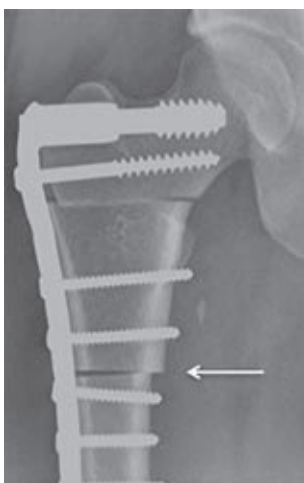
Anteroposterior X-ray of a proximal femoral allograft. A radiolucent line cannot be identified; there is full contact (white arrow): grade 1.
